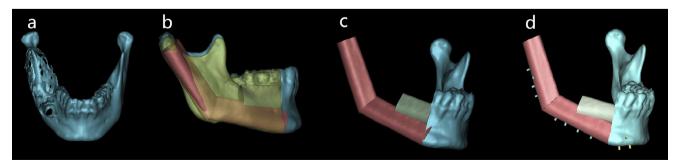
Preoperative design procedure: (a) CT shows the tumour; (b) the 'mirror' function is used to replicate the corresponding contralateral anatomical structure and to design the fibula flap; (c) the fibula flap is designed; (d) cylindrical-shaped objects are placed on the residual mandible.
